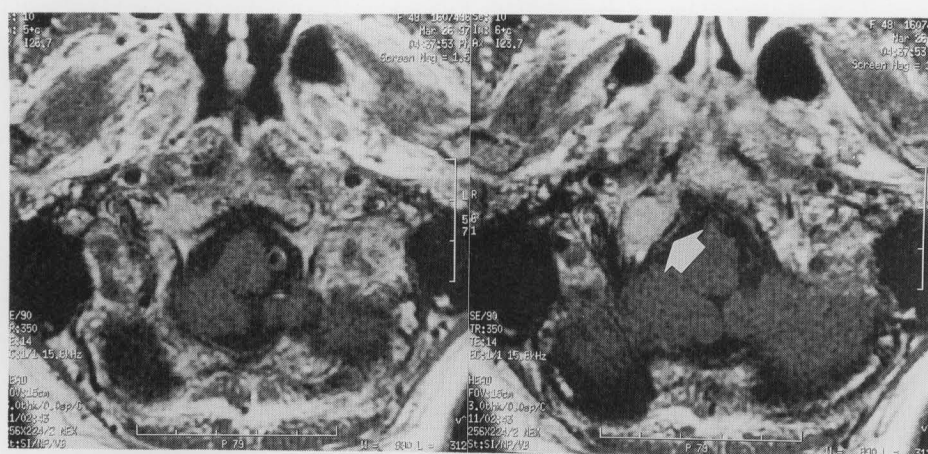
T1-weighted magnetic resonance image with gadolinium-DTPA contrast obtained at the posterior skull base. (left, hypoglossal canal level; right, 2 mm cranial to canal level) A slightly enhanced lesion (arrow), 1.2 cm in diameter, involves the right clival edge, hypoglossal nerve, and canal.
